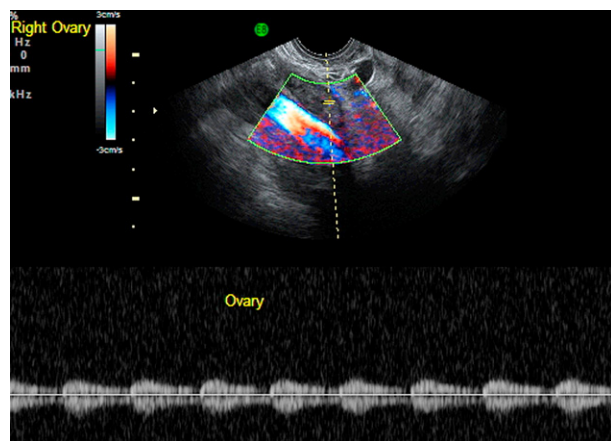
Doppler blood flow velocimetry of the ovary: peripheral area.
